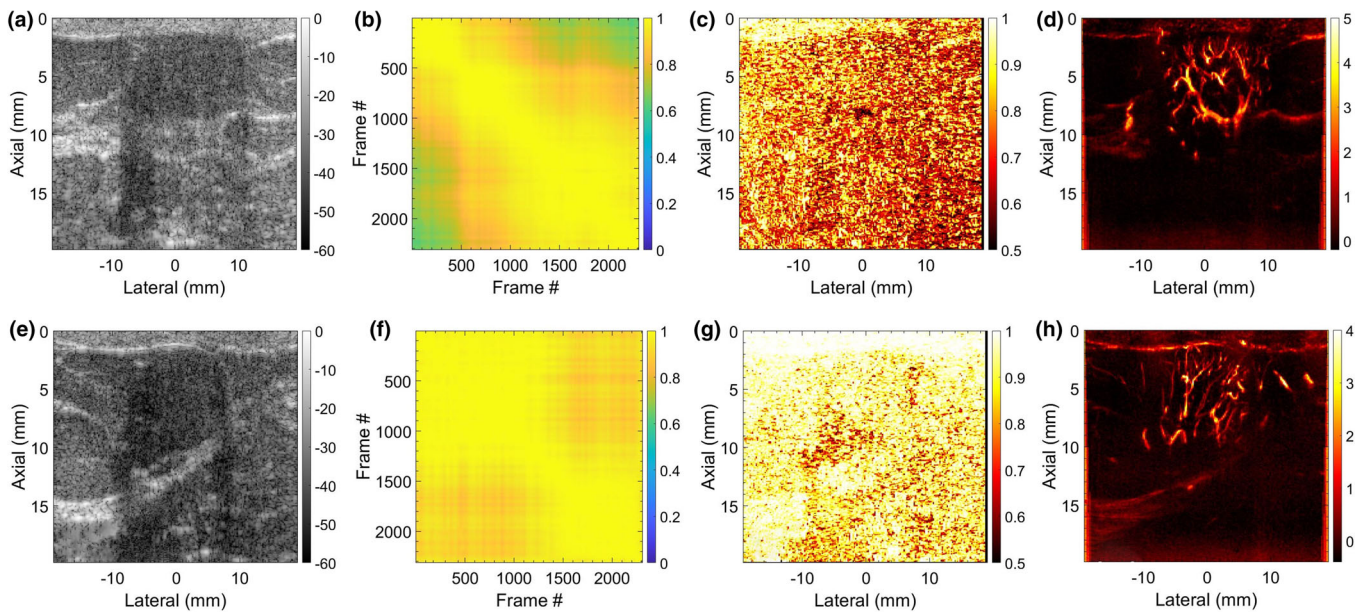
Two representative examples of breast microvascular blood flow (MBF) imaging are displays in Rows 1 and 2, respectively. (a,e) display the breast sonograms. (b,f) display the spatiotemporal correlation matrix (STCM) images quantifying temporal coherency of the Doppler ensemble with respect to the lesion area. (c,g) display the STCM images quantifying spatial coherency of the Doppler ensemble across the entire imaging plane. (d,h) display the respective MBF images. [Color figure can be viewed at wileyonlinelibrary.com]
